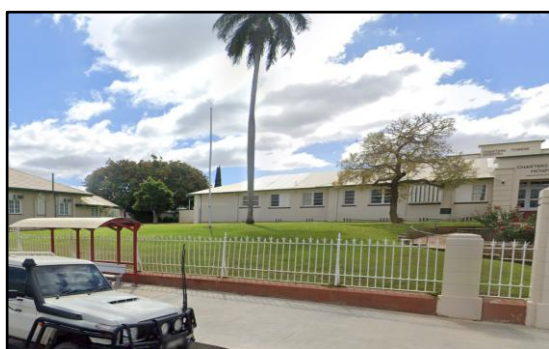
View of the proposed location of the CT Scanner Building looking north-west with Outpatient Building (right) and Allied Health Building (left) (Source: Google Maps 2024).
